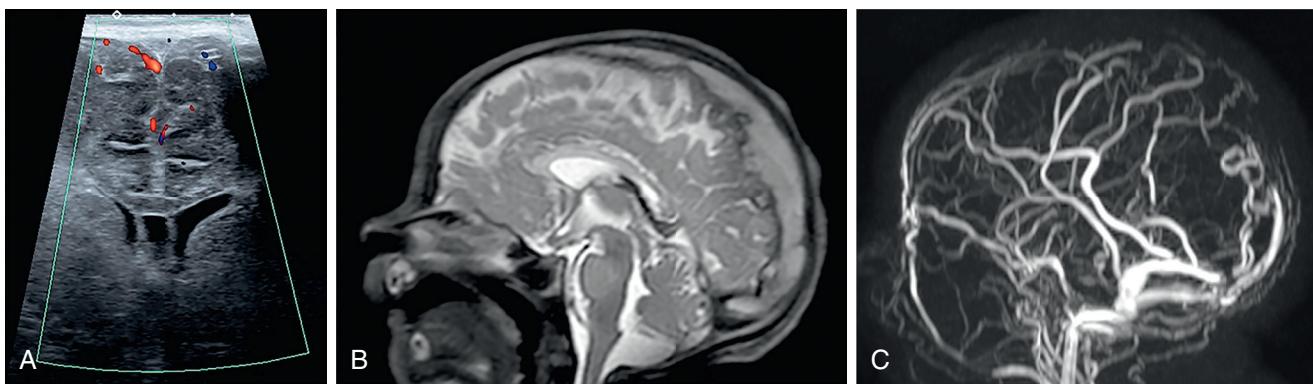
Magnetic resonance imaging (MRI) scans obtained at age 12 days, after development of seizures on day 9. A, Doppler ultrasound does not show any flow in the superior sagittal sinus. B, On the midsagittal T2-weighted sequence, a large thrombus is seen at the level of the superior sagittal sinus. C, Magnetic resonance venography image shows loss of flow at the level of the superior sagittal sinus and straight sinus.
